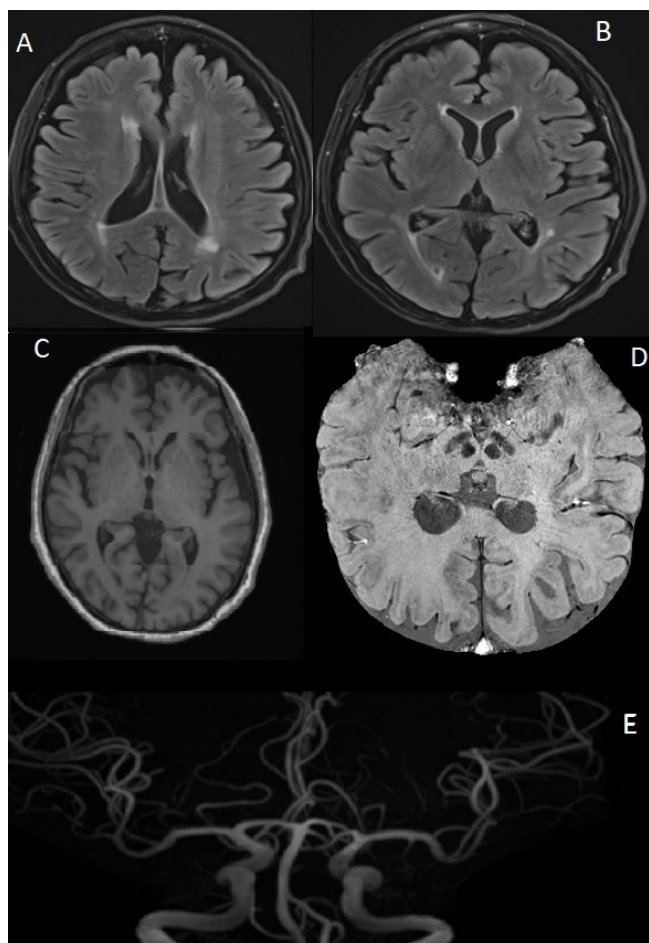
The magnetic resonance brain images show periventricular white matter hyperintensities in the fluid attenuated inversion recovery setting (A and B), which is a common finding of neuropsychiatric systemic lupus erythematosus. The bilateral caudate nuclei and basal ganglia are within normal limits on T1-weighted image (C) and the nigrosome-1 is preserved on both sides on the susceptibility map-weighted image (D). The magnetic resonance angiogram shows no evidence of beading suggestive of vasculitis (E).
